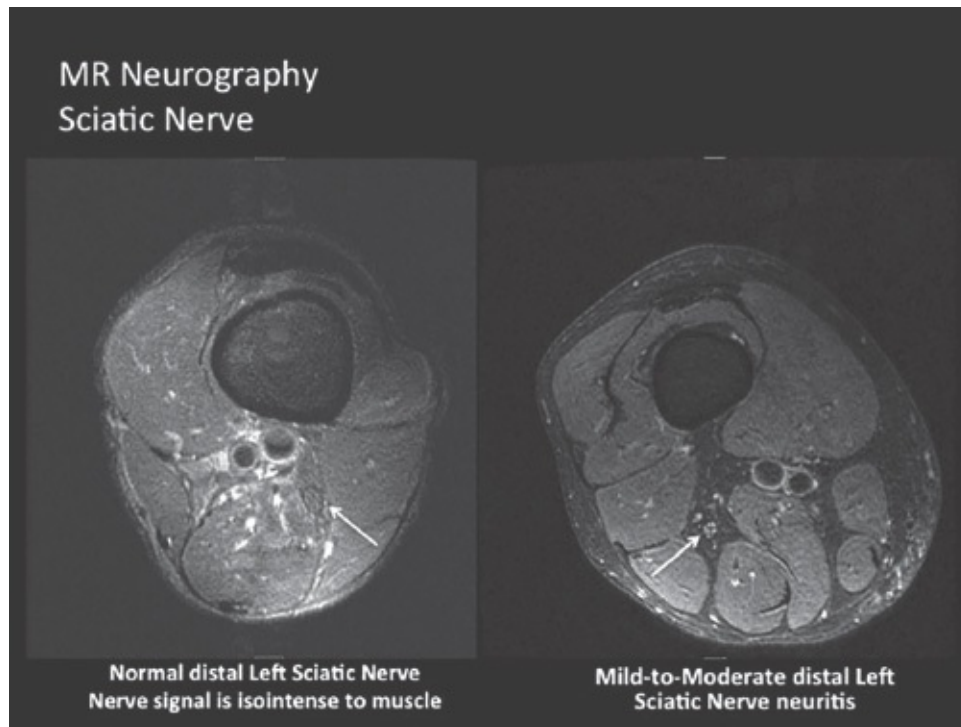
• MRI neurogram showing bright fascicles of the sciatic nerve.
